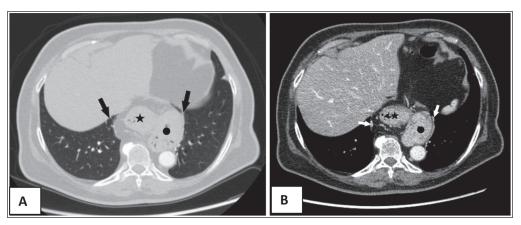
(same patient) A: Transverse computerized tomography (CT) image (parenchyma window). Mixed hiatal hernia. (star: sliding hernia, circle: rolling hernia), atelectatic band appearances due to compression in the pulmonary parenchyma (black arrows). B: Transverse CT image (mediastinal window). Compression-related atelectasis appearances in the pulmonary parenchyma (white arrows)
